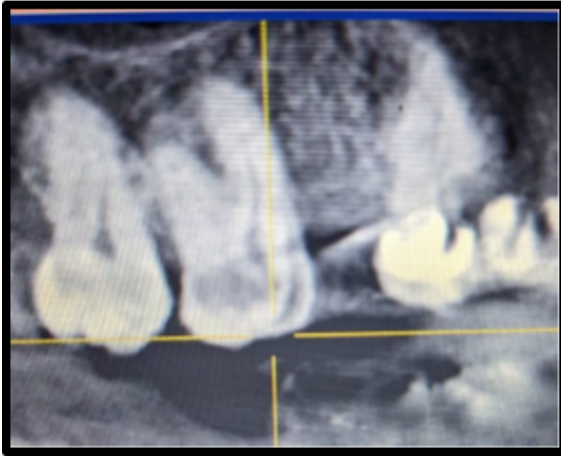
CBCT for determination of root canal curvature.
